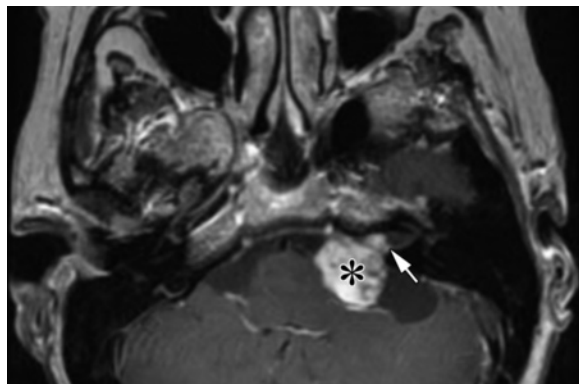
Tumor with a large cerebellopontine angle component. Axial contrast-enhanced fat-suppressed T1-weighted MR image shows a vestibular schwannoma that fills half the IAC (arrow) and has a large cerebellopontine angle component (*), for which the MCF approach is inadequate.
